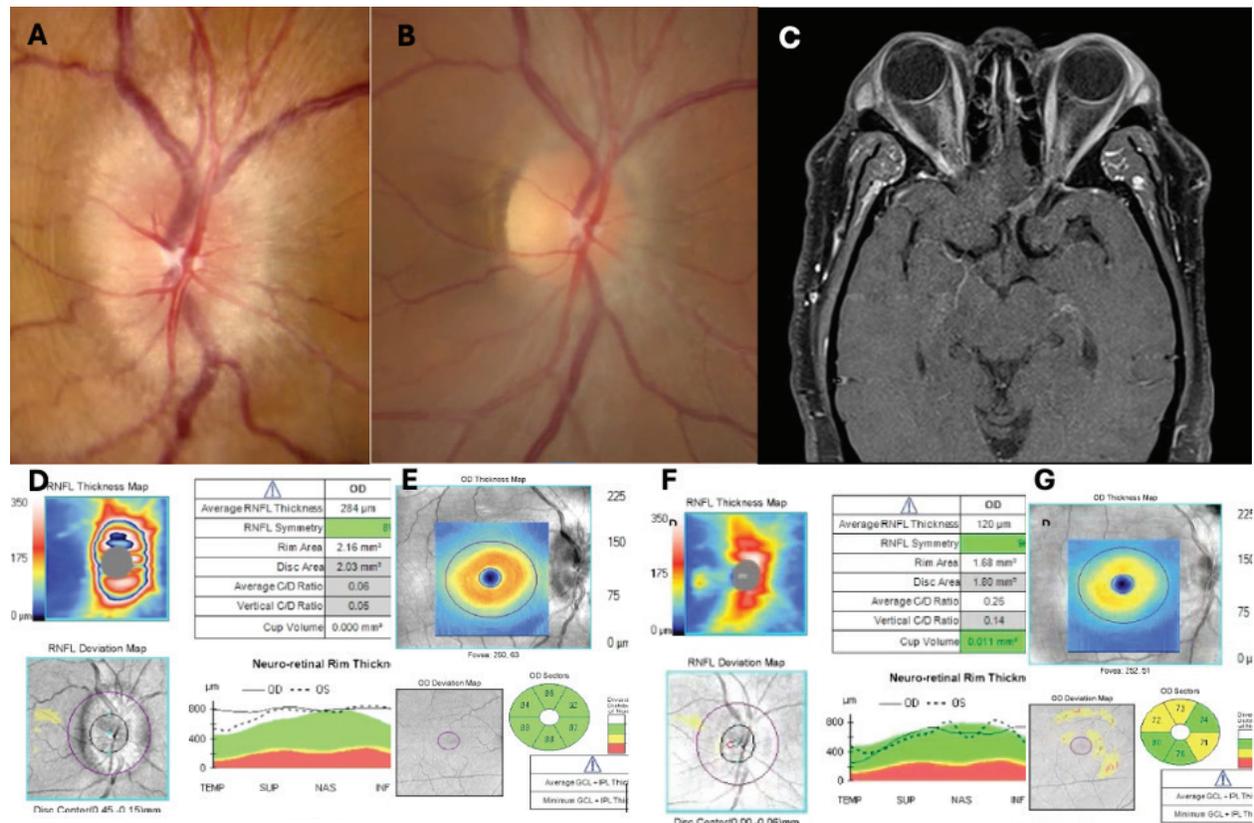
Fundus image, MRI, and OCT in idiopathic ON.
